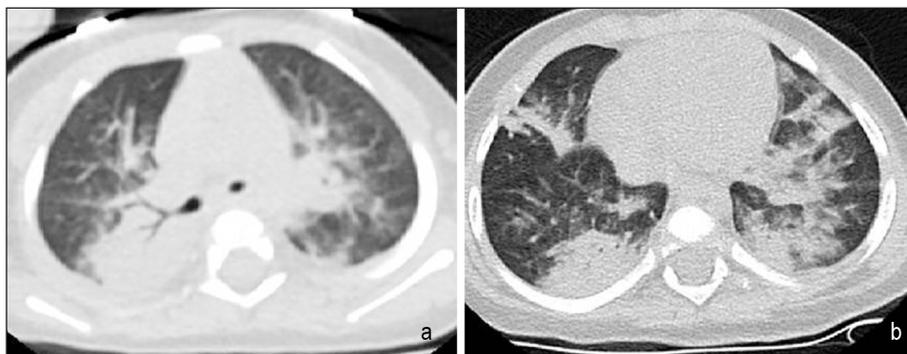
Chest computed tomography images on the third day of admission, showing complete-incomplete consolidated areas and ground-glass opacities in the basal segments and perihilar region, more prominent in the middle and lower zones of the bilateral lung parenchyma, and sporadic atelectatic changes.
